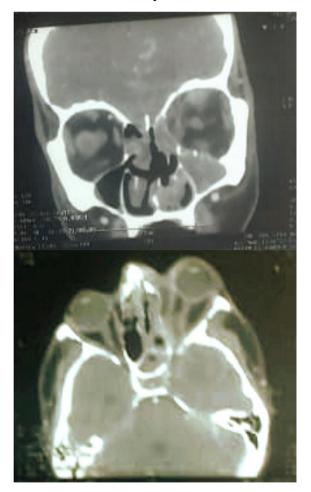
Orbital CT scan with injection showing grade 2-3 proptosis with sinus filling
